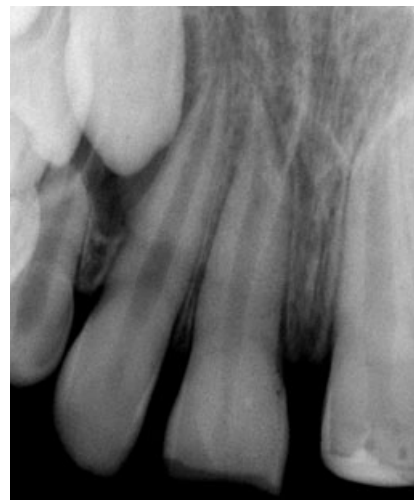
Periapical radiograph of maxillary right central incisor immediately after replantation.
